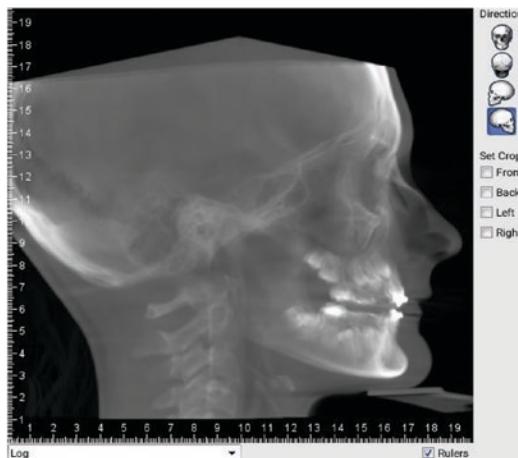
Virtual cephalometric image from a CBCT unit
